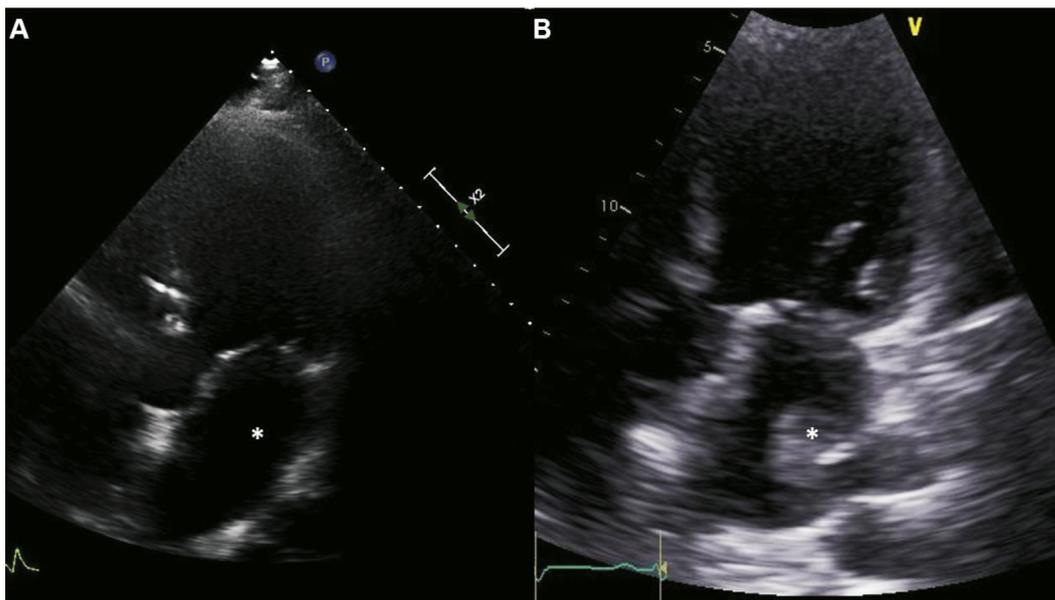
Serial TTE (3 months apart). (A) Apical five-chamber view demonstrates the absence of a cardiac mass within the left atrium (*asterisk*). (B) Three months later, a similar apical five-chamber view demonstrates the presence of a moderate-sized cardiac mass within the LA chamber (*asterisk*).
